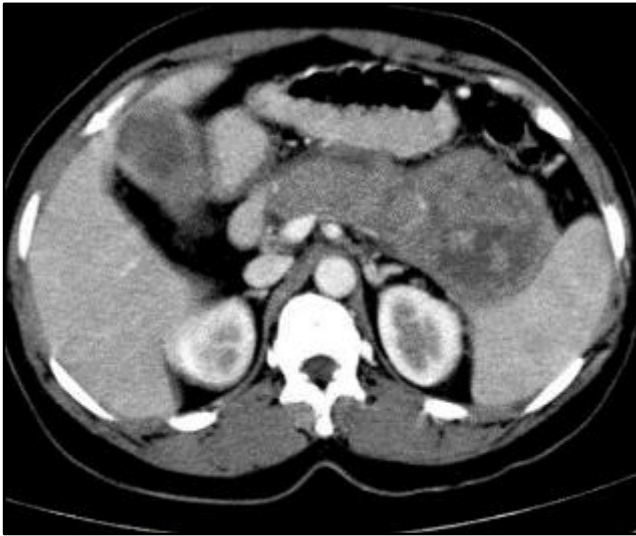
Solid Pseudopapillary Tumour- Axial Contrast-Enhanced CT Image Shows a Fairly Defined Mixed Solid Cystic Lesion in the Region of Pancreatic Tail with Heterogenous Enhancement of the Peripheral Solid Portion of the Tumour.
